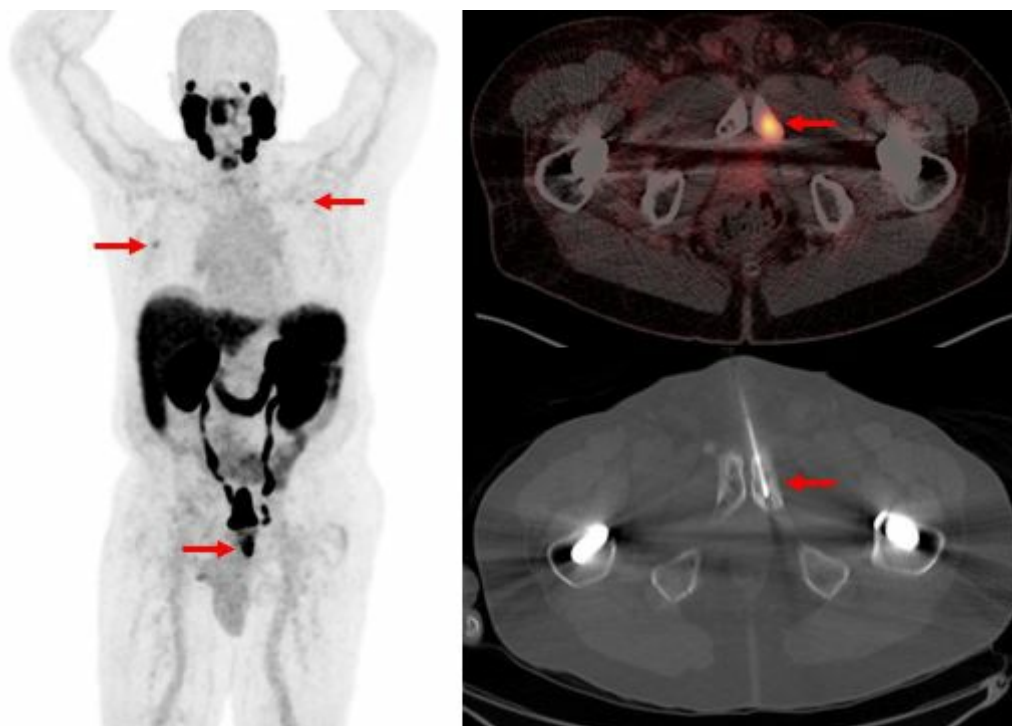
PYLARIFY PET/CT in a 72-year-old man with newly diagnosed Gleason 8 prostate cancer, PSA 5.1. PET/CT demonstrates three avid osseous foci (arrows). The left pubic ramus focus was biopsy proven to represent metastatic prostate cancer.
